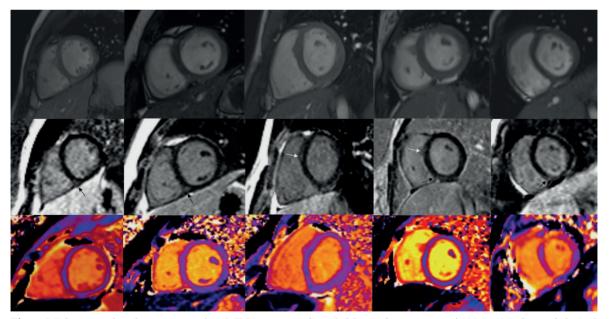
Midventricular short axis cardiac MRI images in five children after a mean of 123.2±62.7 days of clinical diagnosis of MIS-C. First row shows no significant finding on cine images. Second row shows late gadolinium enhancement (LGE) confined to posterior right ventricular insertion points in patiens 1, 2, 4, 5 (black arrows) and anteroseptal wall adjacent to the septal papillary muscle attachment in patiens 3, 4 (white arrows). Third row demonstrates abnormal native T1 mapping which was greater than 1060 msec, on same localisations as LGE (second row) in all patients.
